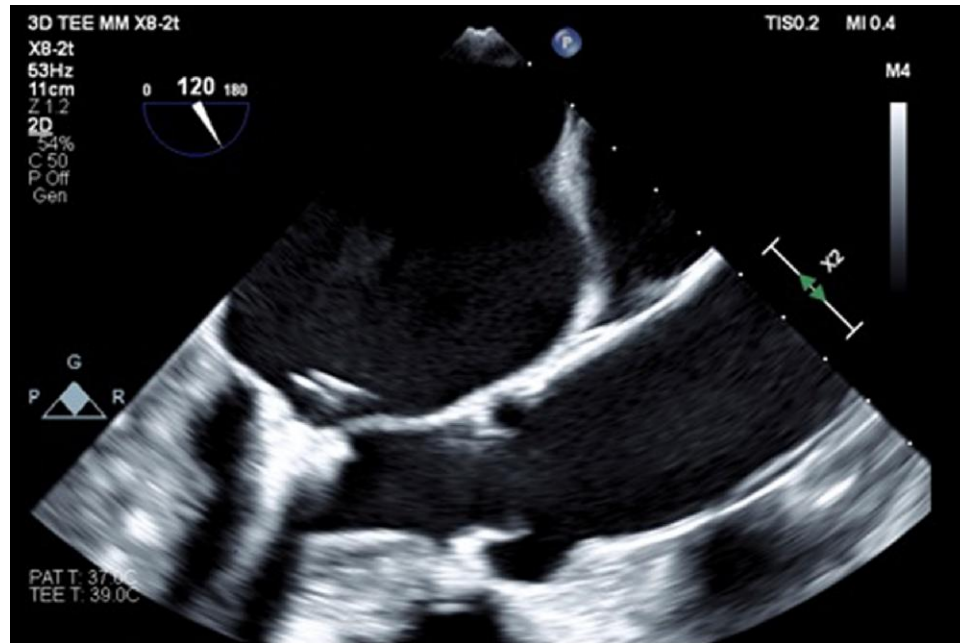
Echocardiogram—post-clip insertion.
